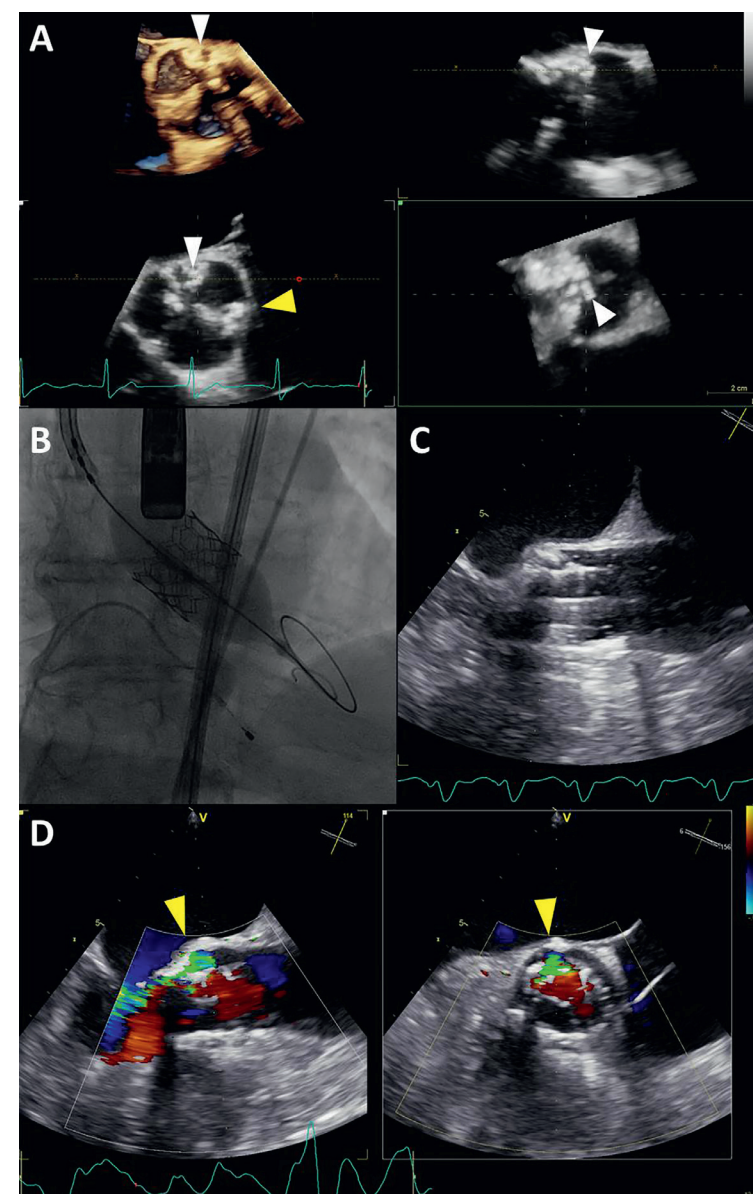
Multimodality imaging during transcatheter aortic valve replacement (TAVR). (A) Perioperative 3-dimensional transesophageal echocardiography (3D-TEE) revealed severely calcified tricuspid aortic valve (AV). Particularly prominent calcifications were at the level of left- and non-coronary cusps commissure (white arrowheads) and at the level of left- and right-coronary cusps commissure (yellow arrowhead). (B) Balloon expandable transcatheter valve deployment, guided by fluoroscopy. (C) Concurrent real-time 2D-TEE image of the valve deployment. (D) Paravalvular aortic regurgitation (PVAR) visualized with colour Doppler biplane echocardiography (yellow arrowheads). PVAR originates at the level of highest annular calcification burden. The circumference of the PVAR is 20% of the prosthesis frame (short axis view on the right side), suggesting moderate PVAR according to Valve Academic Research Consortium-2 (VARC-2) criteria.⁴⁴
